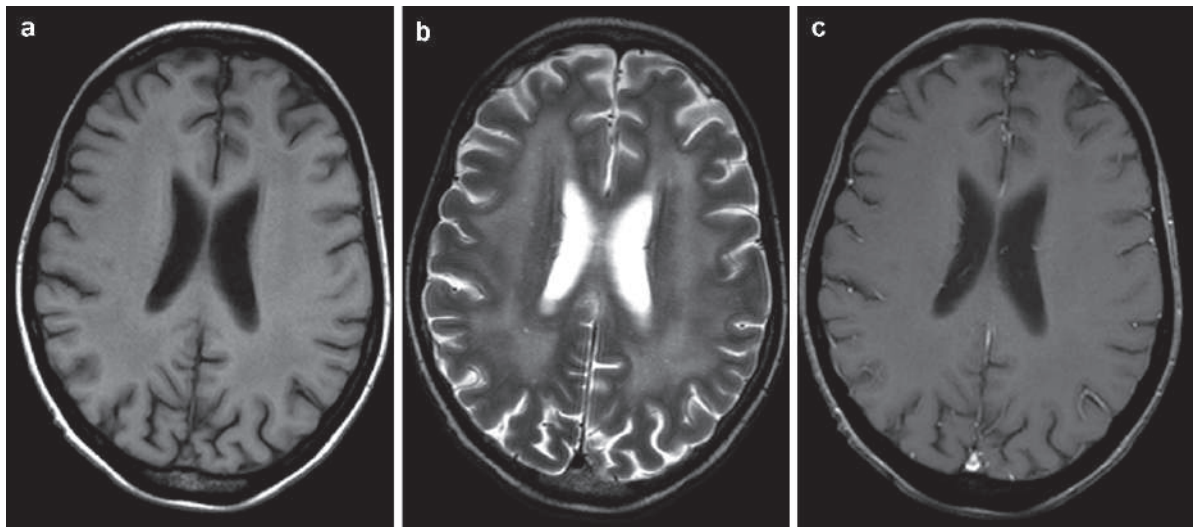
Axial T1W (a), T2W (b), and T1W postcontrast brain MRI of a patient with ALL treated with methotrexate show diffuse leukoencephalopathy of the centrum semi-ovale bilaterally (b), with no contrast enhancement in (c)
